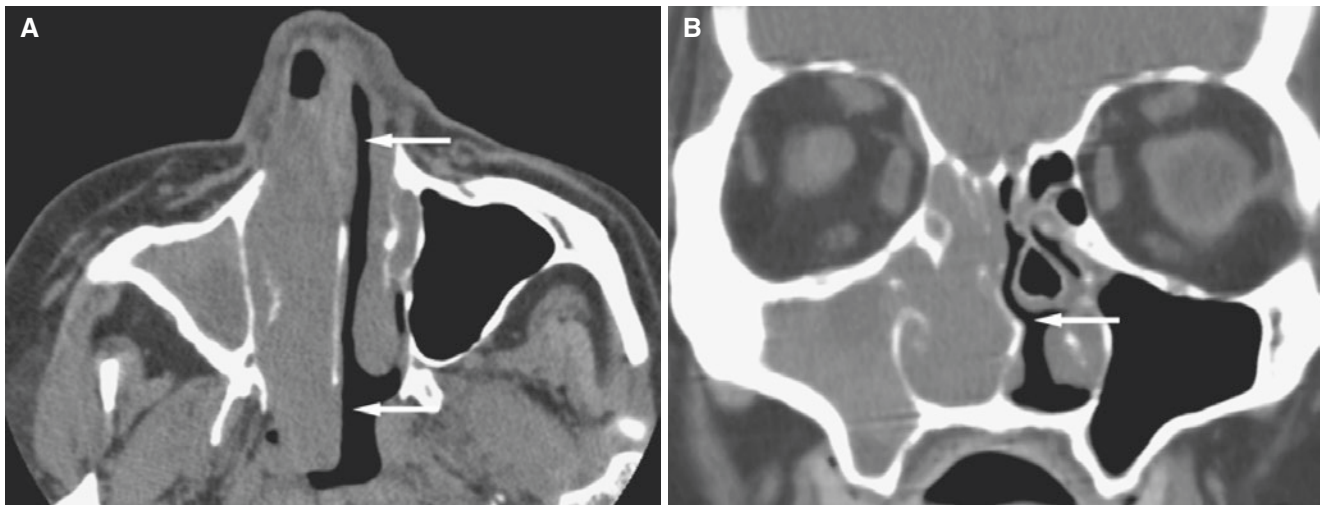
Inverted papilloma; 71-year-old male with history of nasal papilloma that developed malignancy. (A) Axial CT image shows soft-tissue mass in the right nasal cavity with some deviation of the nasal septum extending into the nasopharynx (arrows). (B) Coronal CT
